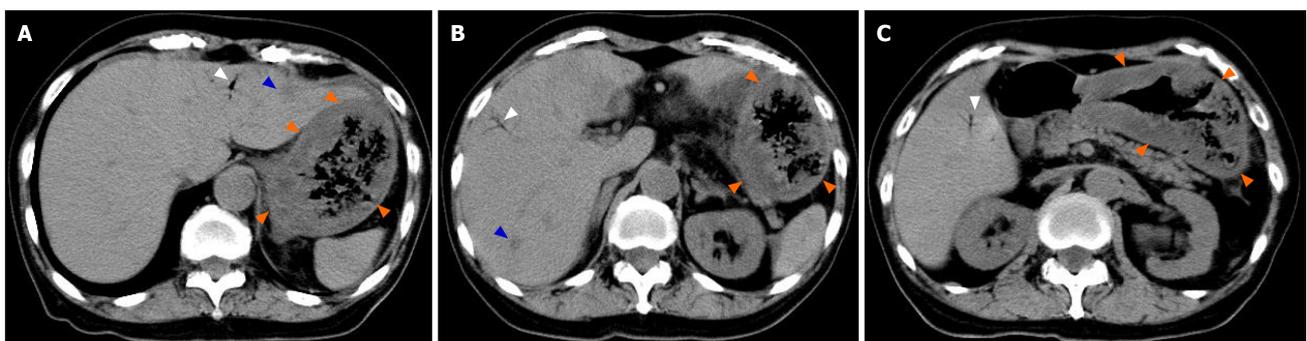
Abdominal computed tomography (day 11). Marked thickening of the gastric wall (orange arrow), suggestive of hepatic portal venous gas (white arrow), and low-density areas (blue arrow) were found.
